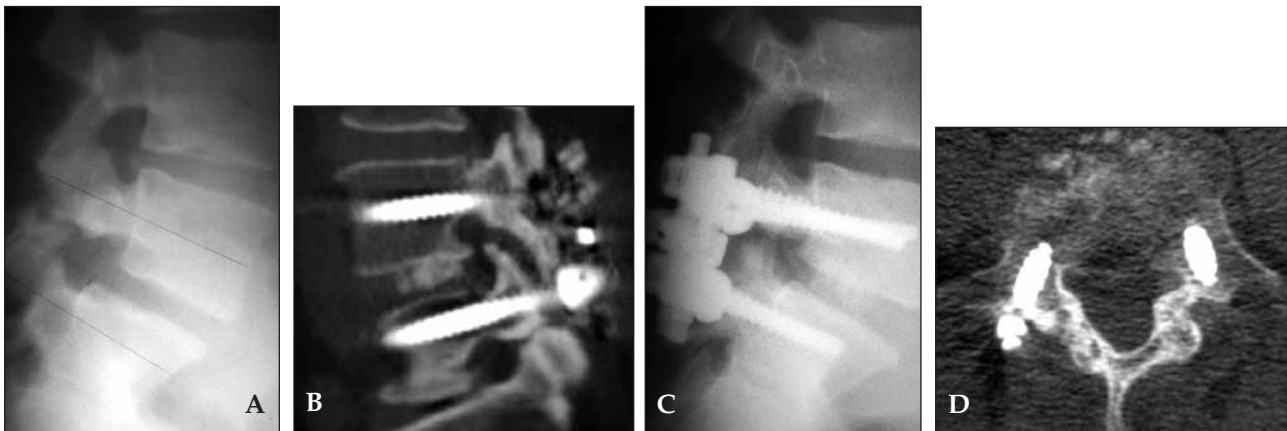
Complete posterior fusion occurred while anterior fusion was not observed in one case. A; Preoperative direct lateral X-ray, B; postoperative direct lateral X-ray, C; Pseudoarthrosis is demonstrated by direct lateral X-ray in the late postoperative (12 month) period. D; Posterior fusion was found to have developed in this case.
